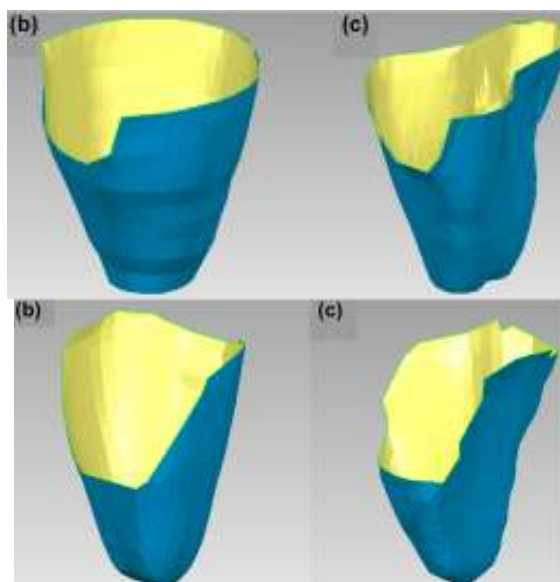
(top) High-speed SP measurements with 3D reconstruction obtained during peak diastolic and peak systolic phases. (bottom) the 3D geometry obtained during peak diastolic and peak systolic phases, respectively, following segmentation and registration of the raw MRI data.
